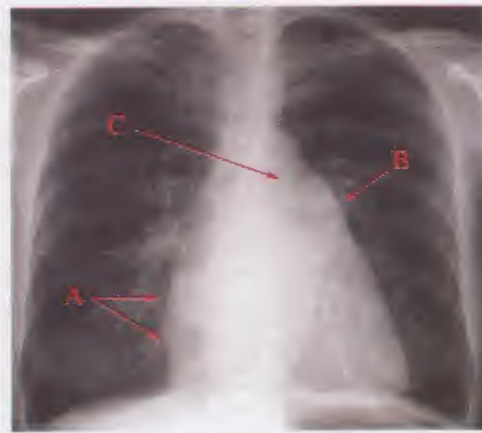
PA chest x-ray showing left atrial enlargement (due to mitral stenosis) with double density of the right atrium (A), straightening of left cardiac border due to left atrial appendage enlargement (B), and splaying of the carina with elevation of the left bronchus (C)
